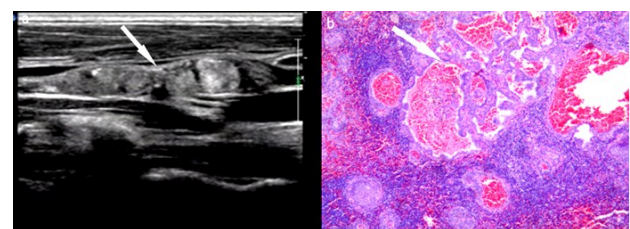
A 48-year-old woman with PTMC. Ultrasound hinted US-LNM: the disappearance of the hilum structure, visible clump hyperechogenicity zone and MC, no CDFS within the nodule. Pathologic report (B) showed that this PTMC nodule presented central lymph node metastasis. The magnification of the pathological picture was 4 \times 10.
